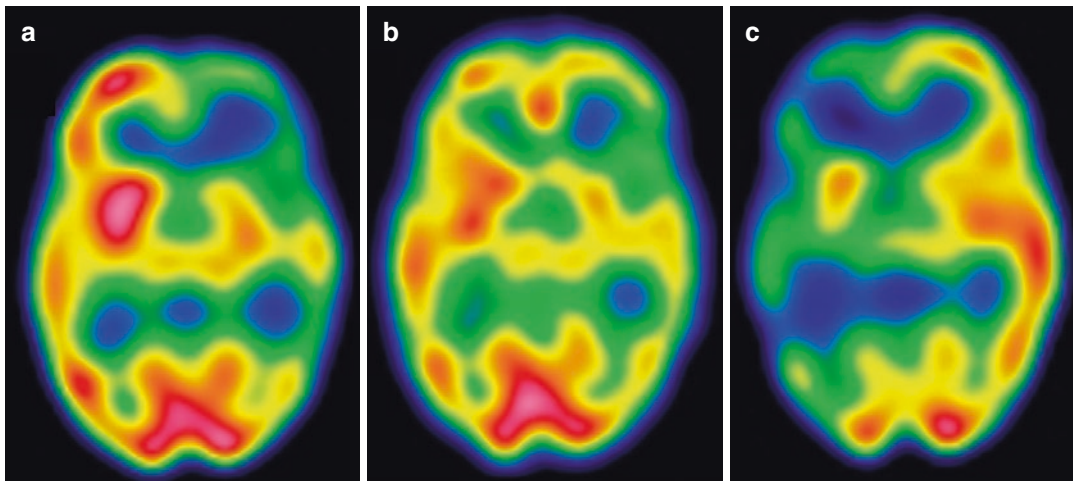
Ictal and interictal SPECT scans with manual injection in 3-year-old male with intractable epilepsy as compared with ictal SPECT using the automated injector. (a) Interictal SPECT images demonstrate diffuse prominent hypoperfusion involving left frontotemporal region. (b) First ictal SPECT attempt. The injection was performed 40 s after onset of seizure. Seizure duration was 46 s, and therefore this late ictal SPECT scan which redemonstrated the hypoperfusion in left frontotemporal region, with similar perfusion pattern seen in interictal SPECT. (c) Repeated ictal SPECT using the automated
